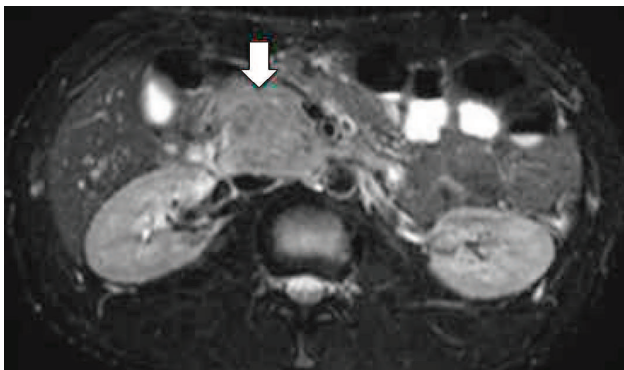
Fat-suppressed T2-weighted magnetic resonance (MR) image shows a bulky circumscribed homogeneously hyperintense mass in the pancreatic head (red arrow).
